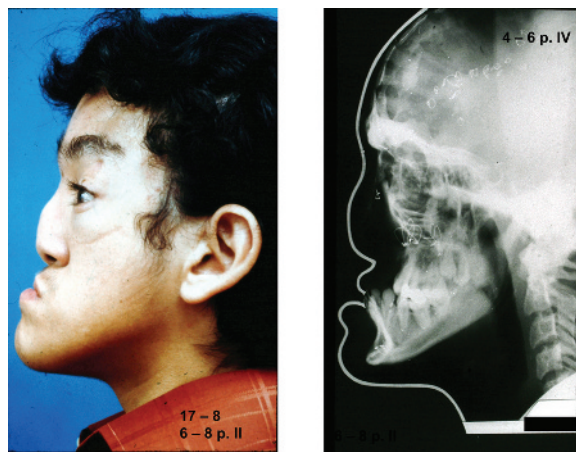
Patients profile at age 17 years and 8 months and his lateral radiograph at age 18.
